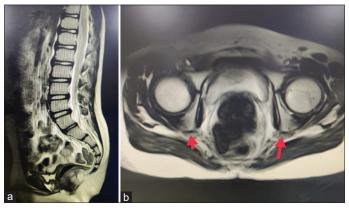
The T2-weighted MRI of the spine displays noticeable thickening of the lumbar nerve roots (a) Sagittal, (b) Axial
